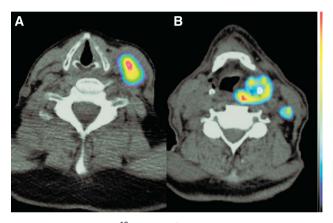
(A) Transverse ¹⁸F-FMISO fused PET/CT overlay image acquired at baseline of a patient with metastatic renal cell carcinoma (mRCC) in the neck acquired at 2.5–3 h p.i (image courtesy of Professors Tim Eisen and Duncan Jodrell, University of Cambridge, UK). (B) ⁶⁴Cu-ATSM fused PET/CT overlay image of a patient with advanced laryngeal squamous cell carcinoma (LSCC) at 80–90 min p.i. The transverse slice includes primary tumour and local lymph node (image courtesy of Dr Anastasia Chalkidou, King's College London, UK).
